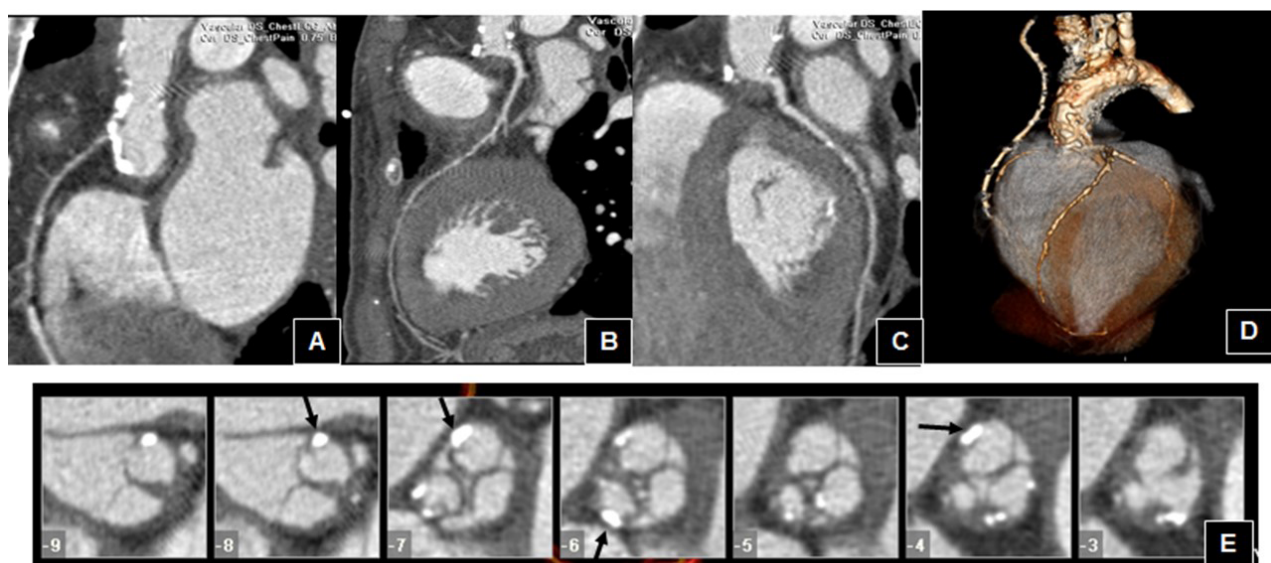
COMPUTED TOMOGRAPHY ANGIOGRAPHY OF THE PATIENT.
